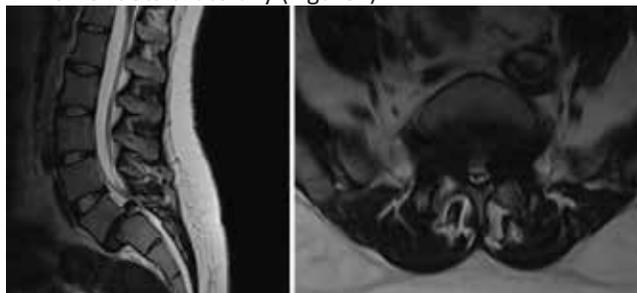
MRI-Lumbar Spine Axial and Sagittal
